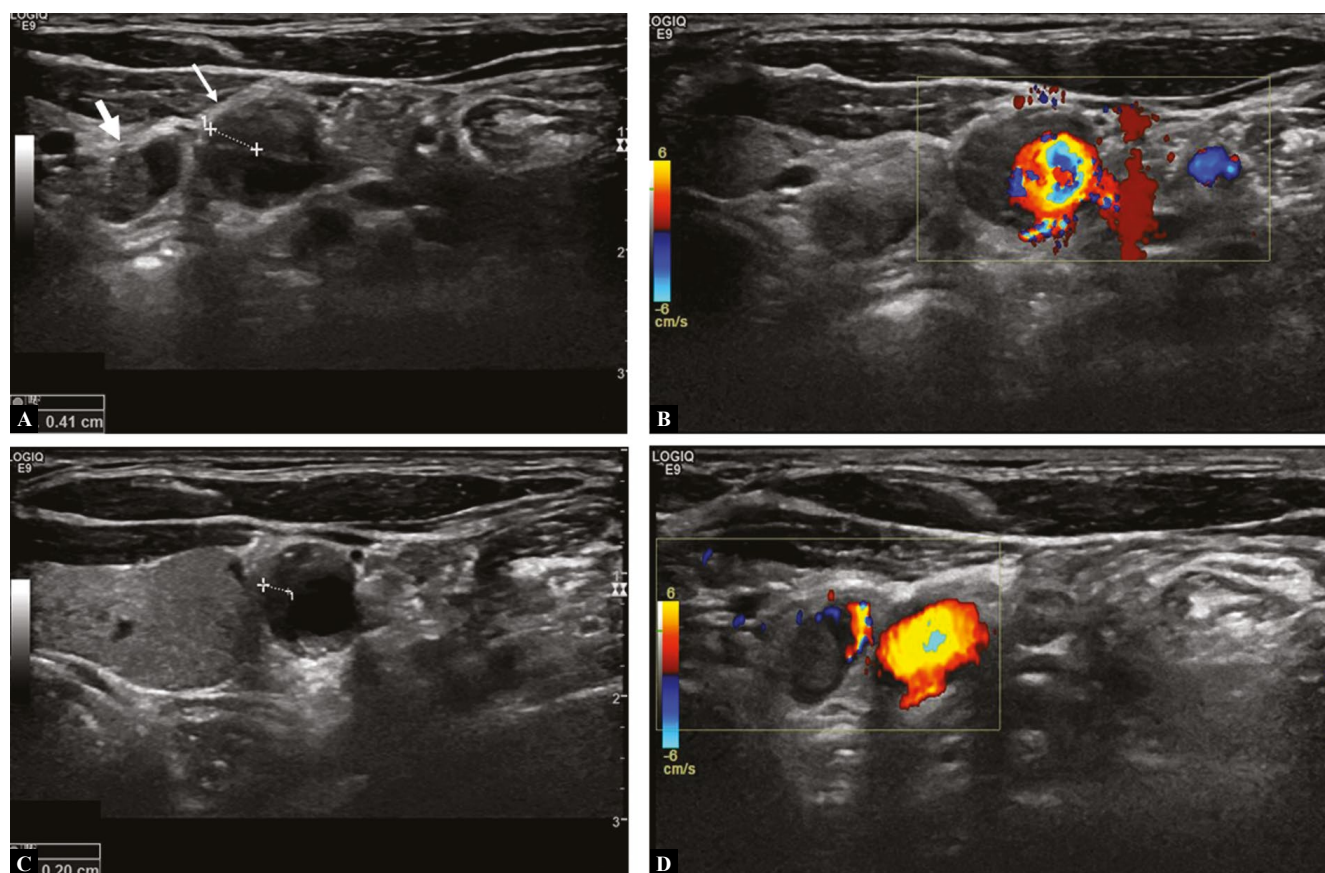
Axial US image (A) immediately after the FNA. There is a 4 mm thick mildly hypoechoic eccentric thickening of the CCA medial wall (thin arrow) causing restriction to the vessel lumen, consistent with an intramural hematoma (calipers). There is no Doppler signal in the hematoma (B), suggesting the absence of a false lumen. Axial B-mode US image (C) a few minutes later, showing the hematoma (calipers) extending cephalad and measuring 2 mm in thickness. Follow-up axial US image one hour later (D) at the same level as (A), showing complete resolution of the hematoma. The parathyroid adenoma is indicated with a thick arrow
